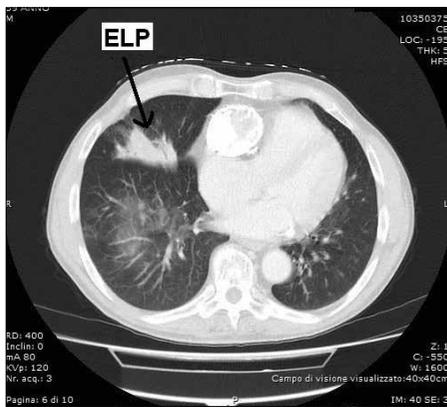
Chest computed tomography shows a consolidation area presenting ground glass opacity in the middle lobe of the right lung
